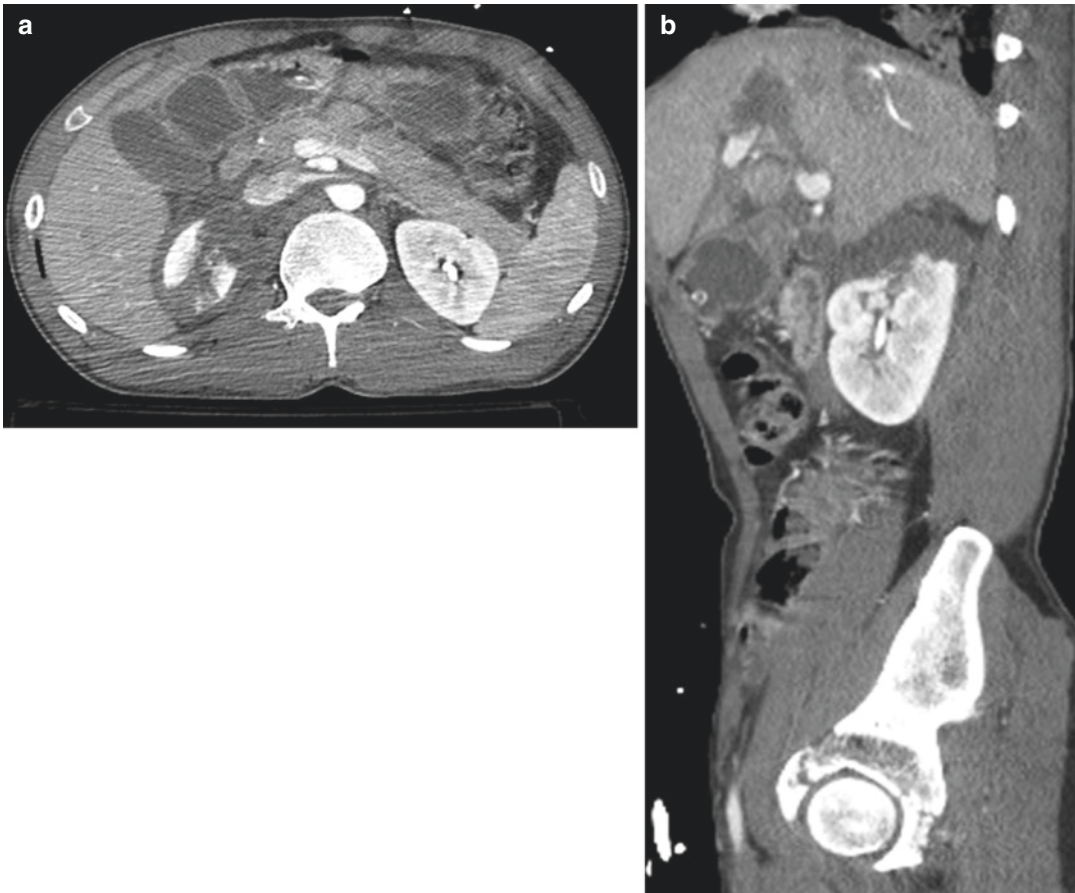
Contrast-enhanced CT, axial scan (a), and sagittal reconstruction (b) show a deep laceration of the upper pole of the right kidney, associated with retroperitoneal hematoma
